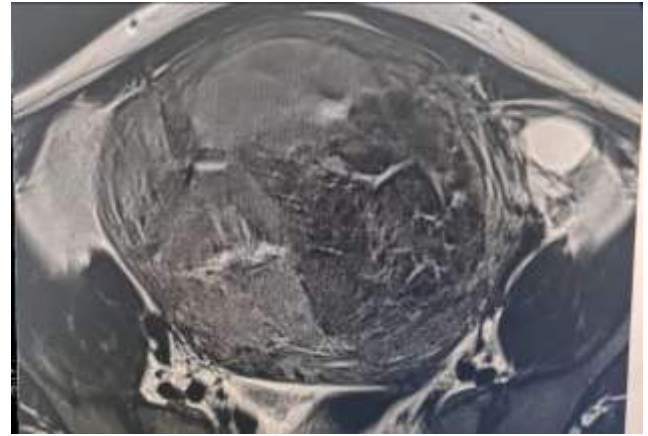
T2-weighted sequence: heterogeneously hyperintense.
